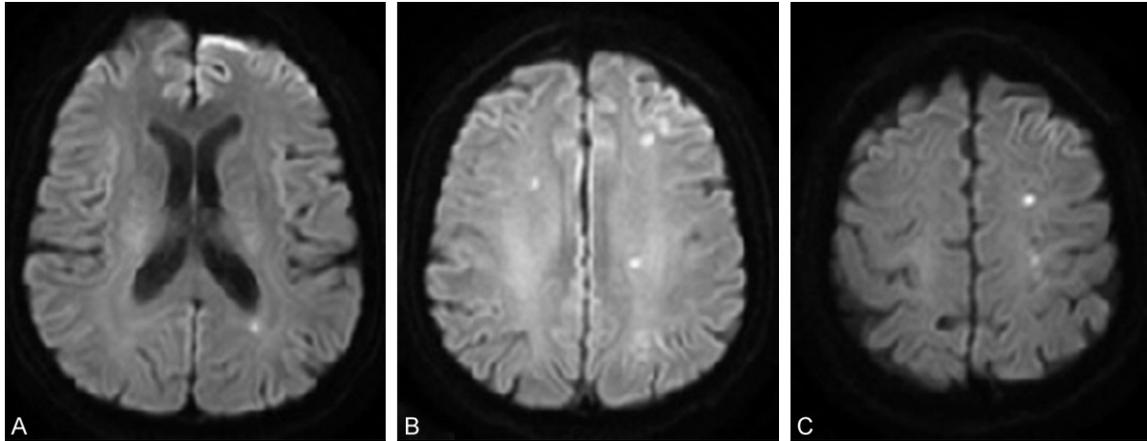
Cranial MRI diffusion weighted imaging (DWI) of Case 4. Multiple infarction lesions - A: 1 lesion near left posterior horn of lateral ventricle; B: 3 lesions in left centrum semiovale, 1 in right centrum semiovale; C: 2 lesions in left parietal lobe.
